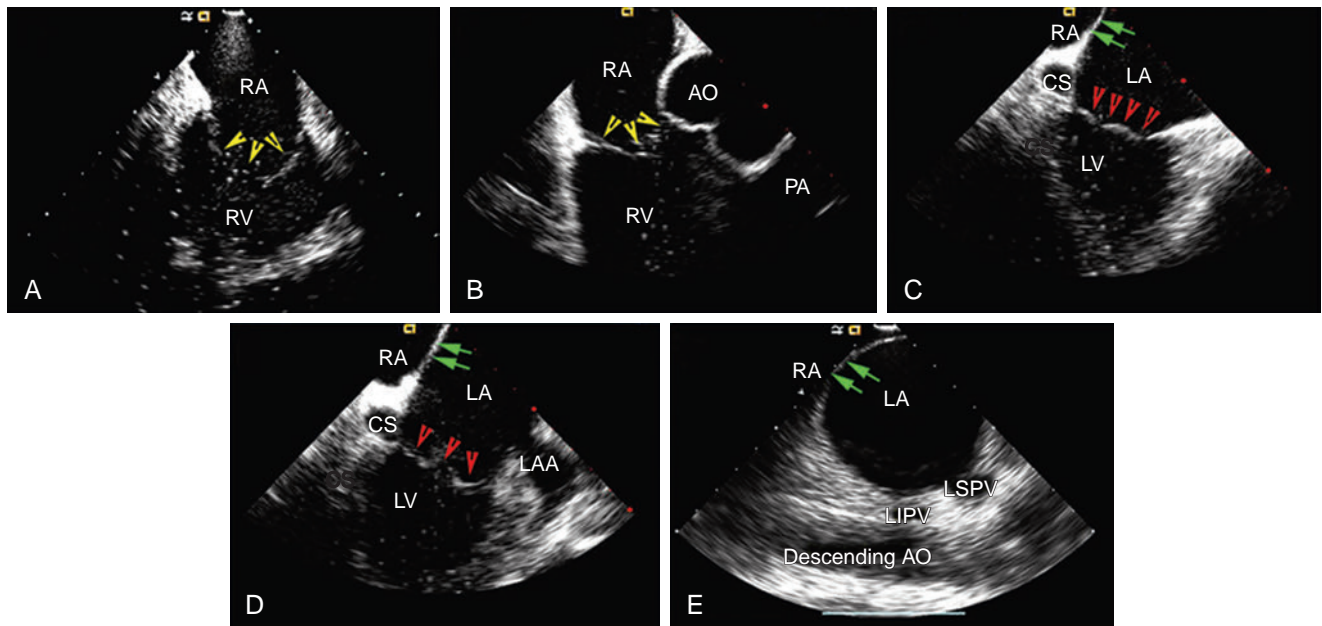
Phased-Array Intracardiac Echocardiography (ICE). Phased-array ICE (AcuNav) serial images with the transducer placed in the middle right atrium (RA) demonstrate serial changes in tomographic imaging views following clockwise rotation of the transducer. Each view displays a left-right orientation marker to the operator's left side (i.e., craniocaudal axis projects from image right to left). (A) Starting from the home view, the RA, tricuspid valve (yellow arrowheads), and right ventricle (RV) are visualized. (B) Clockwise rotation brings the aorta (AO) into view. (C) Further rotation allows visualization of the interatrial septum (green arrows), left atrium (LA), coronary sinus (CS), left ventricle (LV), and mitral valve (red arrowheads). (D) Subsequently, the left atrium appendage (LAA) becomes visible. (E) The ostia of the left superior pulmonary vein (LSPV) and left inferior PV (LIPV) can be visualized with further clockwise rotation. PA, Pulmonary artery. (Courtesy AcuNav, Siemens Medical Solutions, Malvern, PA, United States.)
